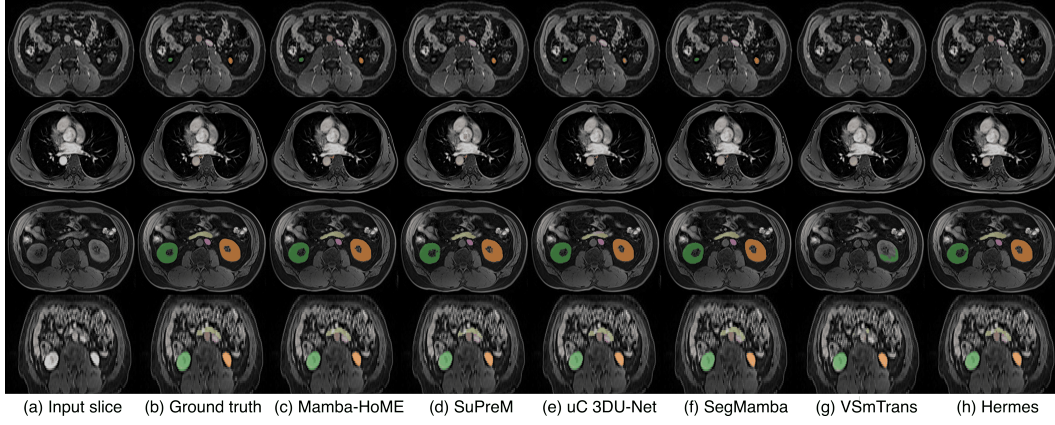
Qualitative comparison of segmentation performance on the AMOS-MRI validation set for six methods: Mamba-HoME (trained from scratch), SuPreM, uC 3DU-Net, SegMamba, VSmTrans, and Hermes. The models are trained on both training dataset of AMOS-CT and AMOS-MRI.
